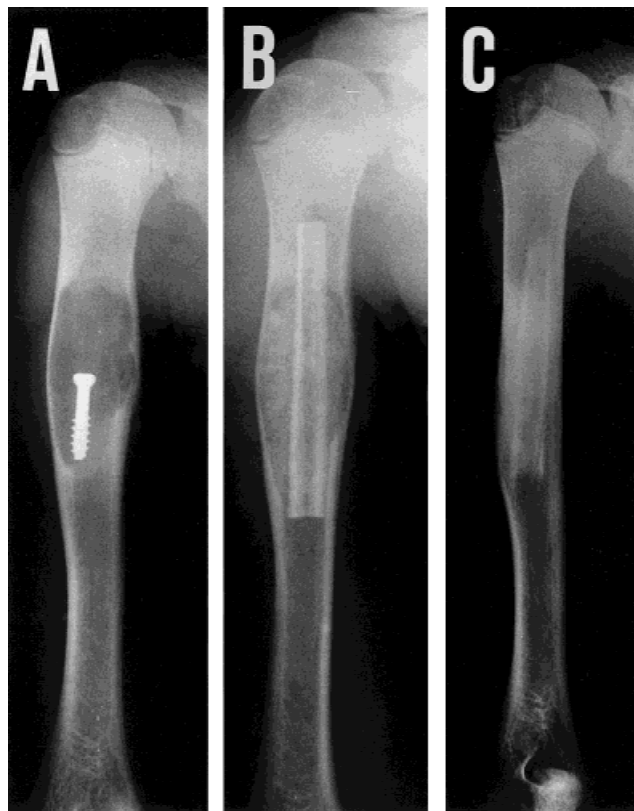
This 13-year-old boy with soreness of the right upper arm had a history of bone cyst of the humerus and had received corticosteroid injection therapy and cannulated screw surgery for the lesion at 8 years of age. A: Radiograph showing recurrent expansile bone cyst over the humerus with a thin cortex and screw in canal. B,C: Healing of the cyst and good bony incorporation of the strut graft at 3 months and 2.5 years postoperatively.
